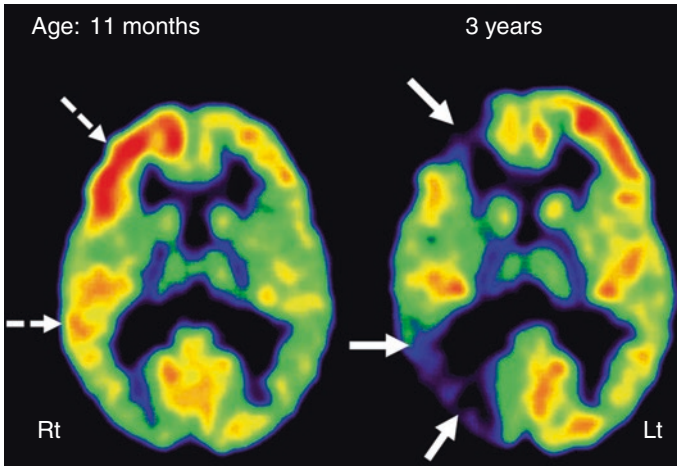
Serial 2-deoxy-2(^{18}F)-fluoro-D-glucose PET scan showing progression of glucose metabolic abnormalities in the affected right hemisphere (MRI showed extensive leptomeningeal enhancement on that side) in a child with Sturge-Weber syndrome. PET scan at 11 months of age showed a transient increase of metabolism, most prominent in the frontal lobe and mild in the temporal cortex (*dashed arrows*). Repeat PET at 3 years of age showed severe hypometabolism in the right frontal and temporal cortices (*solid arrows*)
